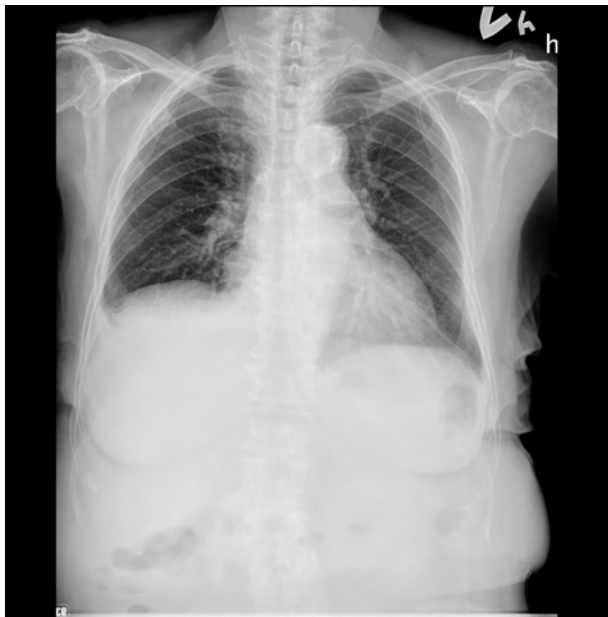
Chest X-ray of a patient with recurrent edema showing cardiomegaly with bilateral small pleural effusion. Atherosclerosis of the thoracic aorta was also noted.
